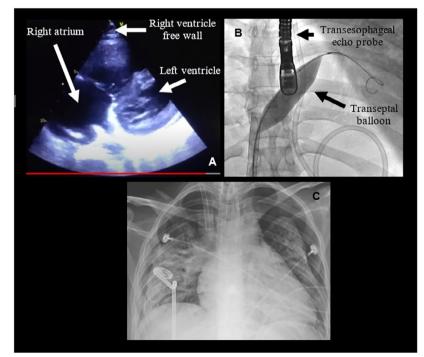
(A) Transthoracic echocardiography after the installation of severe pulmonary hypertension; (B) atrioseptostomy procedure; (C) thoracic X-ray depicting bilateral pneumothorax.
